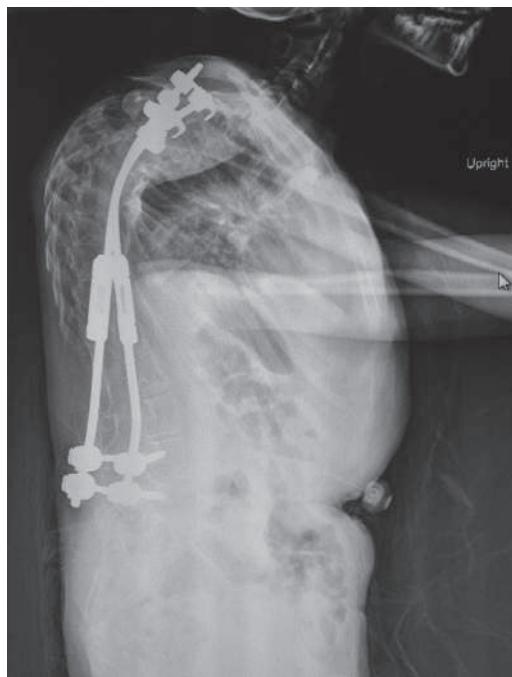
A postoperative lateral radiograph of a skeletally immature patient with severe syndromic scoliosis after placement of growing rods.
